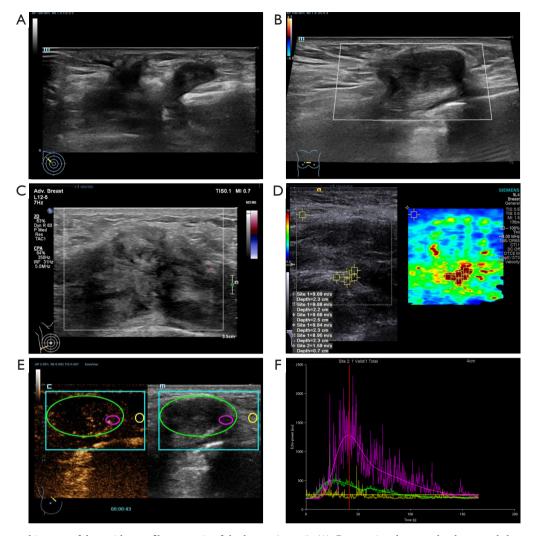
Ultrasound images of desmoid-type fibromatosis of the breast (case 1). (A) Conventional grayscale ultrasound showed a hypoechoic mass close to the muscle layer in the right breast. (B) Color Doppler flow imaging revealed sparse blood flow signals within the smaller mass. (C) Power Doppler flow imaging displayed sparse blood flow signals within the larger mass. (D) Shear wave elastography demonstrated a higher hardness of the larger mass. (E) Contrast-enhanced ultrasound image revealed slightly higher nodular enhancement in some areas of the smaller mass. (The green circle covers the entire mass, the red circle covers a portion of the mass, the yellow circle covers the surrounding contrasting tissue, and the blue box contains areas of interest and control). (F) The contrast pattern was progressively enhanced in the smaller mass. CPA, color propagation angle.
